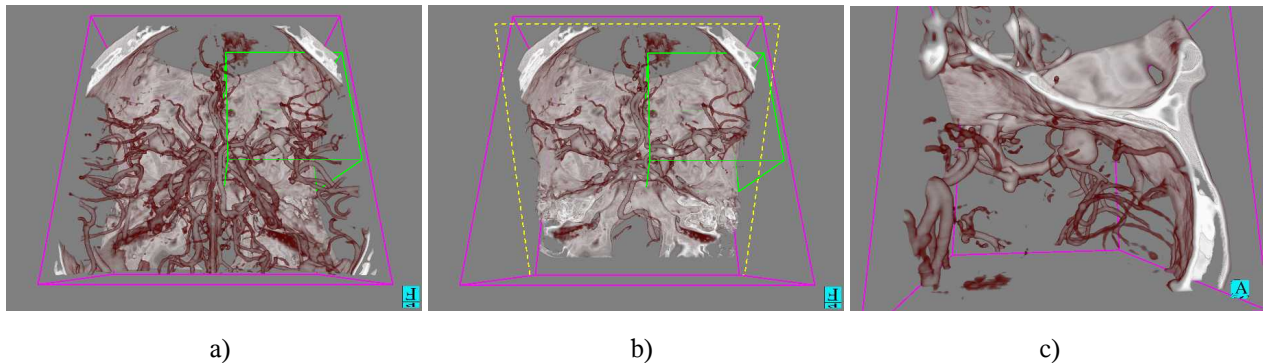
Three example views of an object movie of a CTA Dataset, which show two overview visualizations without (a) and with a clip plane (b), and a zoomed view of the greensub-volume with an aneurysm in the center.
